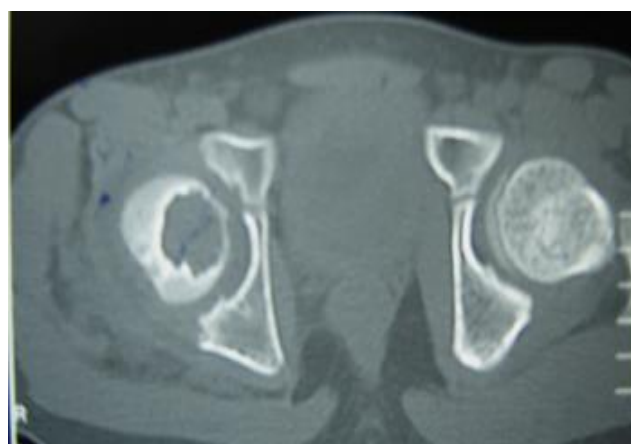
Axial CT of destruction of femoral head and slight involvement of articular area.
